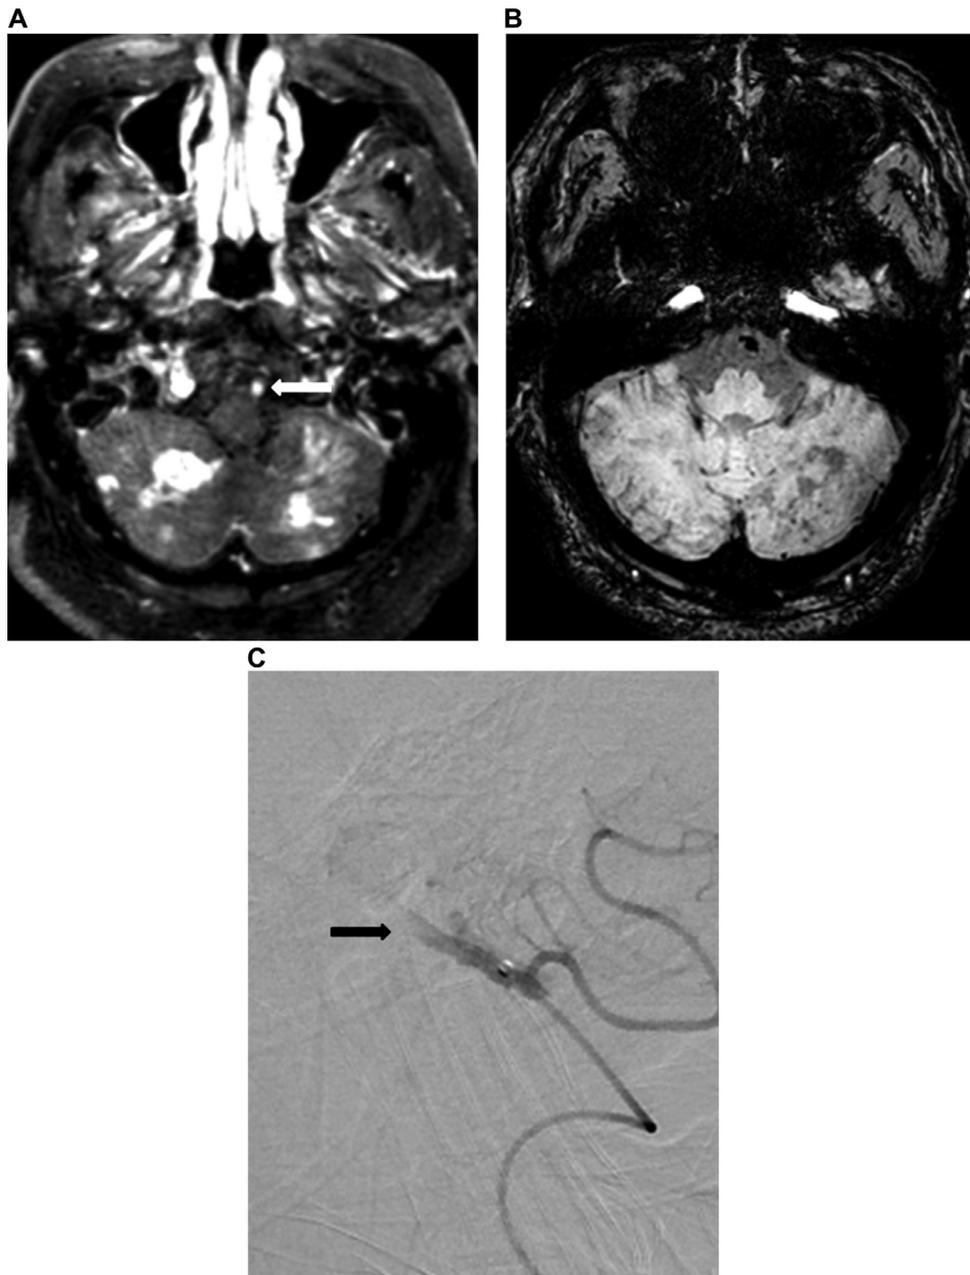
A 75-year-old man with unilateral vertebral artery (VA) and basilar artery (BA) occlusion. A. 3D-BB-ceT1-MRI shows strong enhancement due to contrast stagnation in the left VA (arrow). B. SWI shows a positive SVS in the left VA (arrow). C. Lateral vertebral angiography shows complete occlusion and a thrombus with underlying atherosclerosis (arrow).
